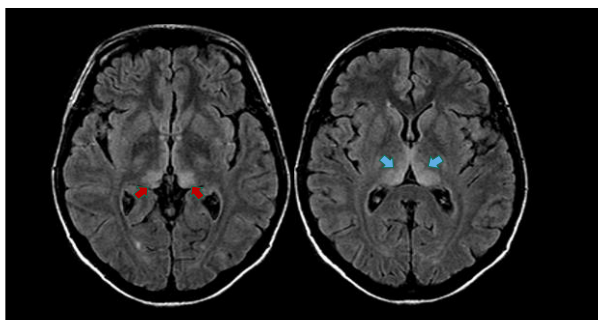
MRI brain of maternal representative case of variant CJD; Axial FLAIR images at the level of the basal ganglia showing symmetrical pulvinar (red arrows) and dorsomedial thalamic (blue arrows) abnormal bright signal. This combination gives the "hockey stick" appearance
